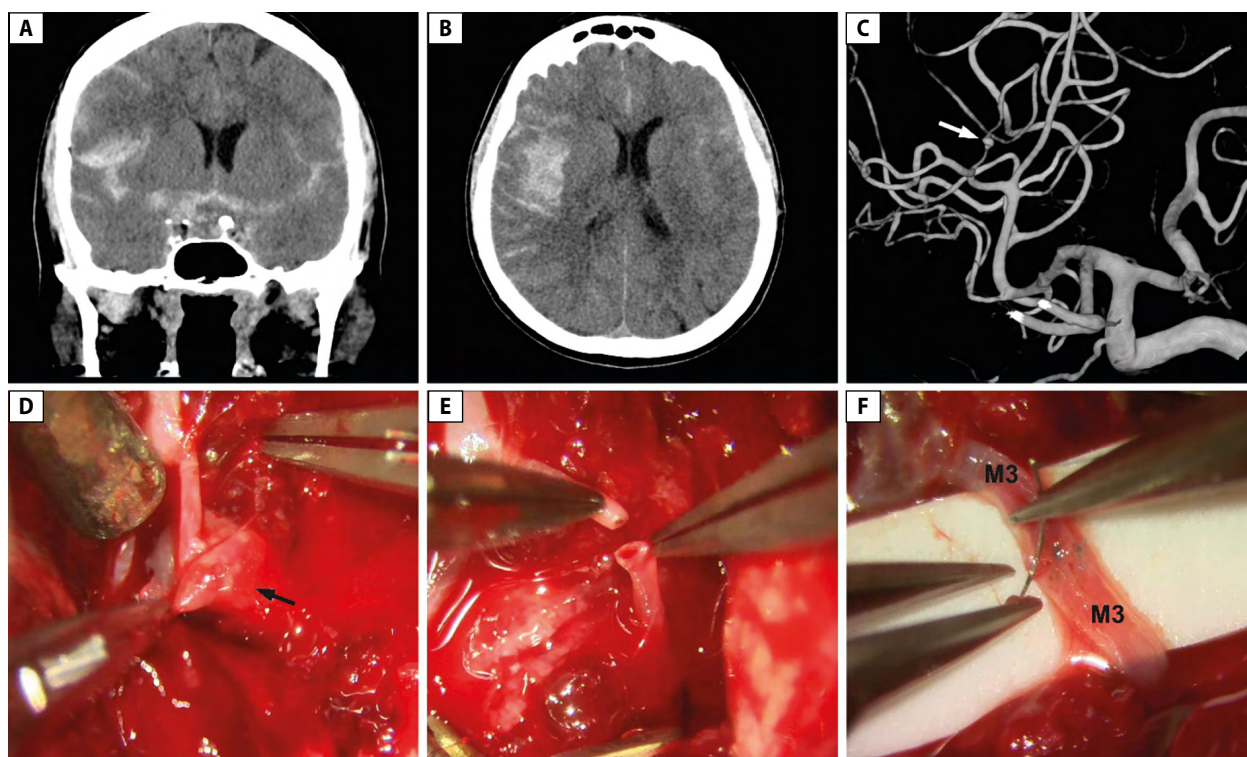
A, B. Subarachnoid hemorrhage and intracerebral hematoma of the right frontal lobe on initial CT; C. 3D CTA reconstruction of the RMCA, spastic M3 branch with fusiform aneurysm (white arrow); D. Intraoperative view of the fusiform aneurysm dissection (black arrow); E. Mobilized proximal and distal M3 stump after fusiform aneurysm resection; F. End-to-end microanastomosis of the M3 branch. CT – computed tomography; RMCA – right middle cerebral artery
